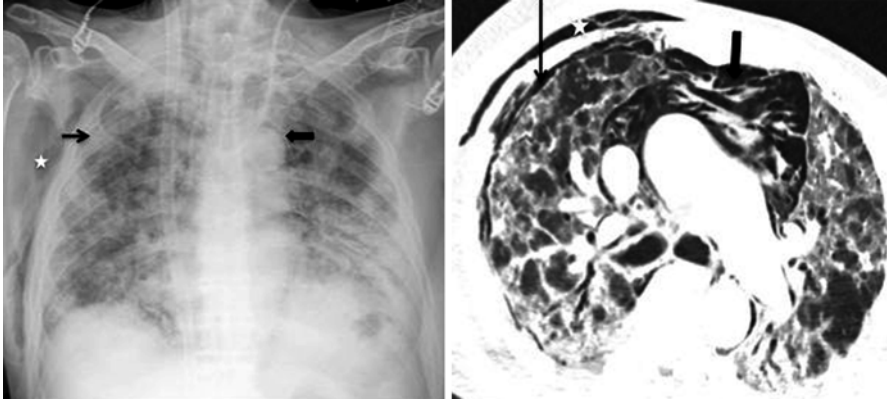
A 55-year old female with respiratory failure on ECMO with difficult ventilation. Chest radiograph (*left*) shows widespread bilateral alveolar opacification with a subtle right pneumothorax (*thin black arrow*), pneumomediastinum (*thick black arrow*) and right lateral chest wall surgical emphysema (*white star*). The severity of the complications is more evident on the CT (*right*) allowing for better characterisation of the extent of the pneumomediastinum
